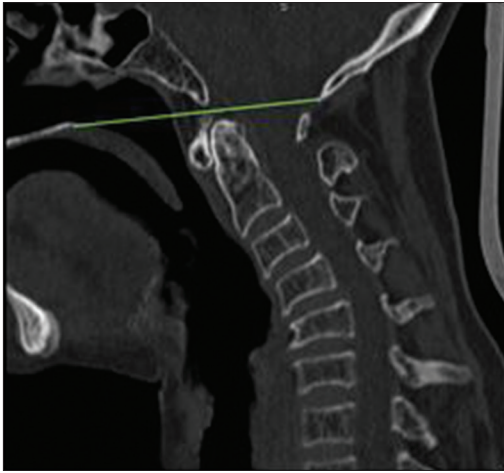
Sagittal section of computed tomography scan showing the Chamberlain line
